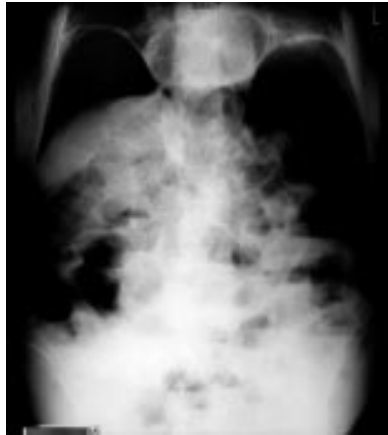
Plain abdominal radiograph.
